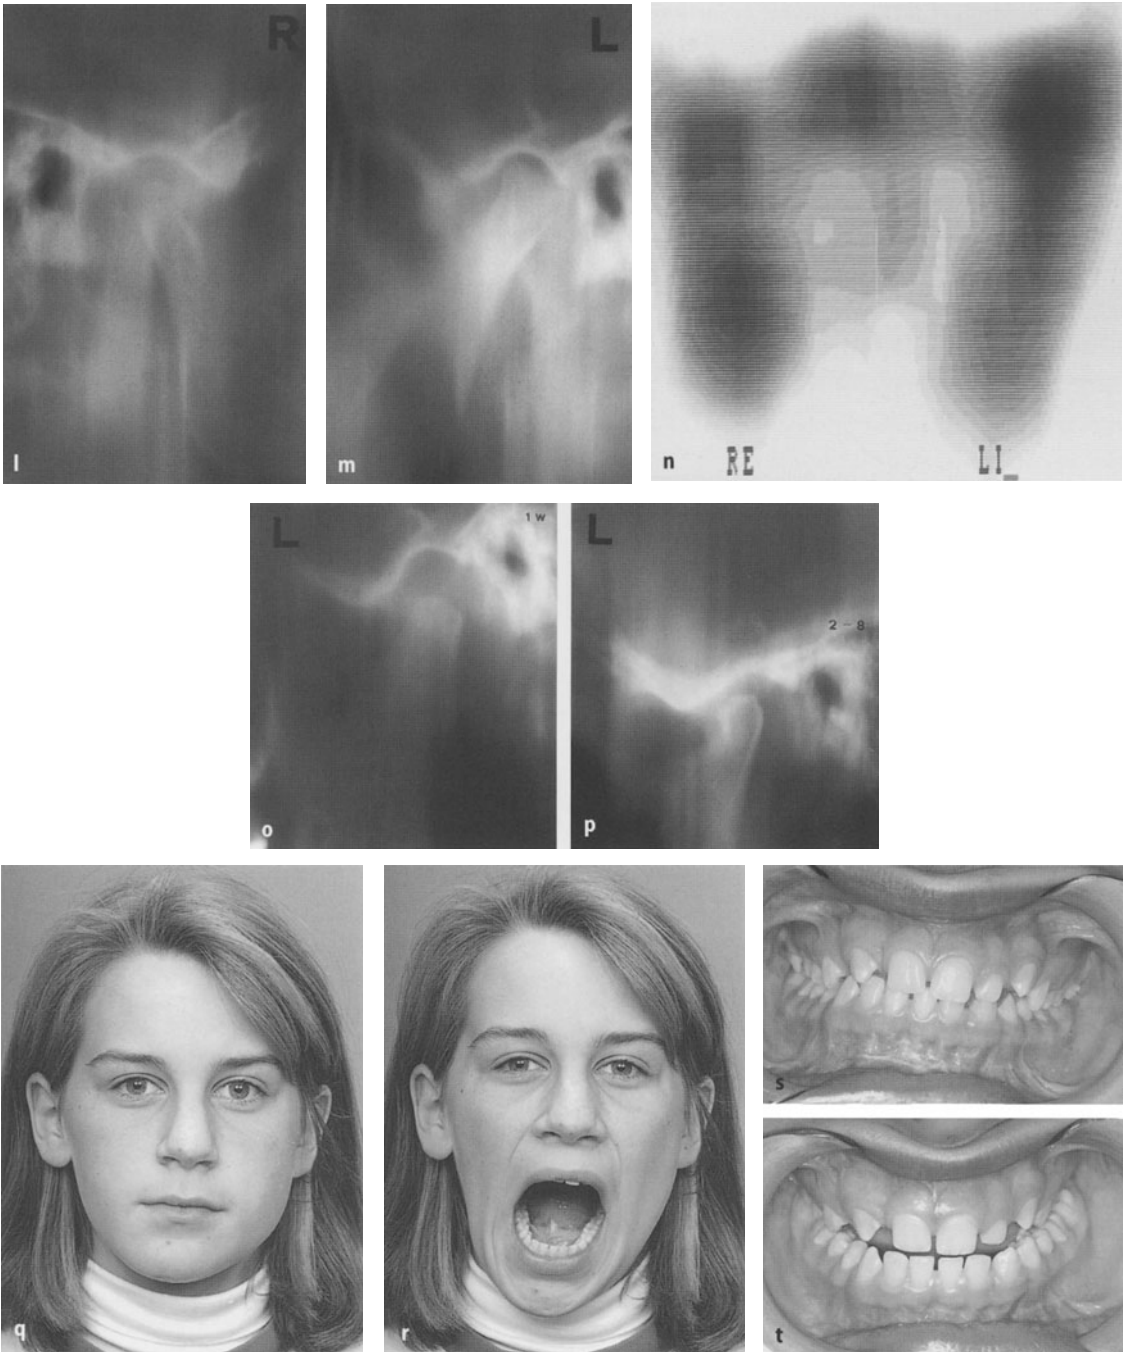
Unilateral active hybrid form with H.E. predominance and contralateral hemimandibular hypoplasia. l, m The TMJ ramus tomograms, taken at age 13 years and 9 months, confirm that both condyles are not normal in size and shape. There is irregular hypoplasia on the right side and long and thick neck, and a large and deformed condyle on the left side. n The scintigraphy confirms clear hyperactivity in the left condyle. o, p TMJ tomograms from the left side, the one taken 1 week and the other 2 years and 8 months after condylectomy: a small new condyle has formed spontaneously. q, r Eleven months after high condylectomy only and chin repositioning, there is still some facial asymmetry. Mouth opening is within the normal range, with less deviation than before. s, t Occlusion and unimpeded forward movement without deviation 1 year and 2 months after condylectomy
